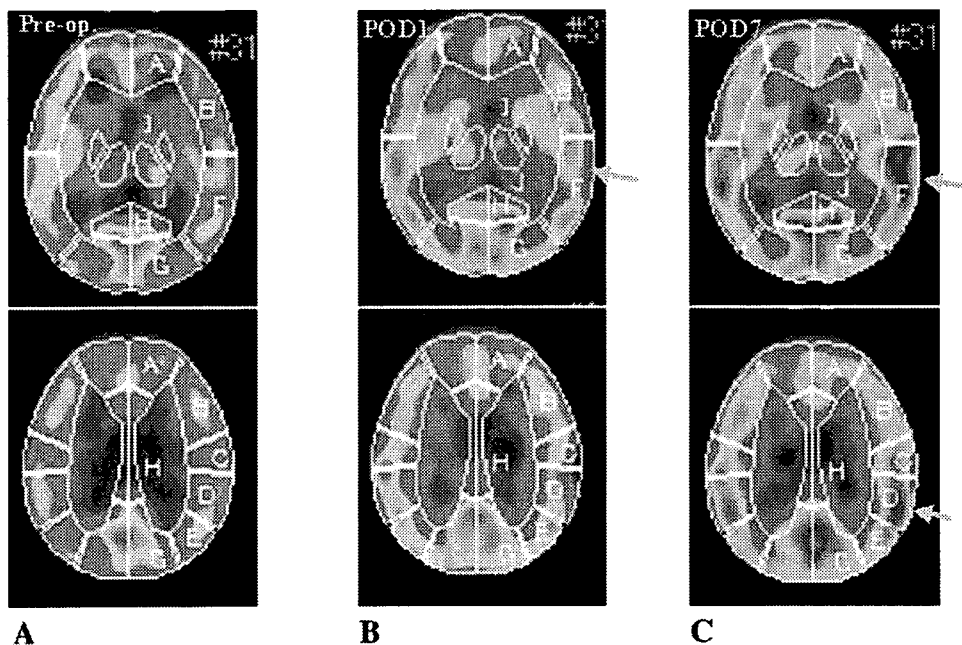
Case 3. ^{123}I -IMP-SPECT scans before surgery (A) and 1 (B) and 7 days (C) after surgery. Mild increase in CBF was detected on the side of anastomosis 1 day after surgery (arrow in B). The focal intense increase in CBF at the site of anastomosis (arrows in C) was evident 7 days after surgery, in accordance with the manifestation of aphasia and sensory disturbance on the right hand.
